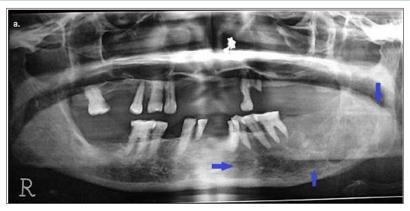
Orthopantomogram of the patient showing a multilocular osteolytic lesion in the left posterior region of lower jaw.
